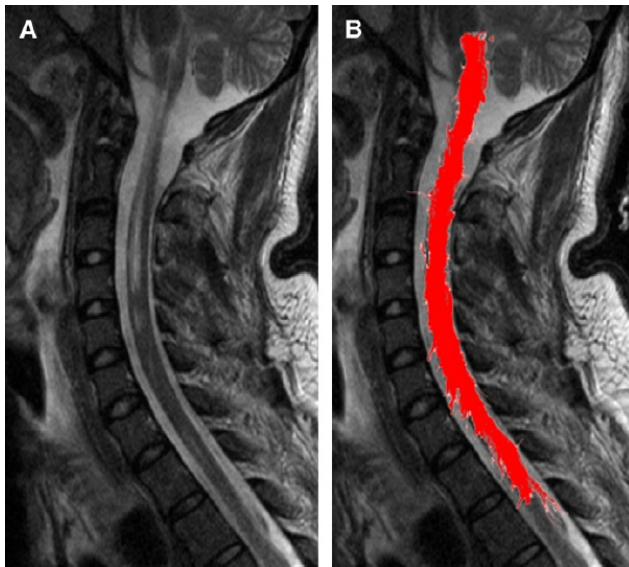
A patient who has MELAS and spinal cord involvement. (A) Midsagittal T2 image shows the central area of high signal in the cord from C2-C4. (B) FT map coregistered and projected on T2-weighted image shows an unaltered shape of the white matter tracts. In this disease, accumulation of extracellular water does not warp the fiber.
